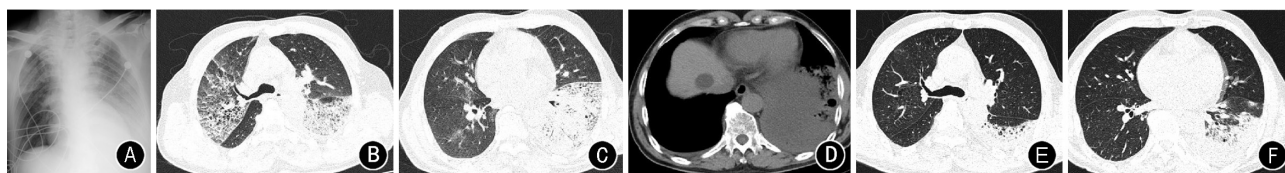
Chest X-ray and CT of a 65-year-old male diagnosed with H7N9 show bilateral, extensive, diffuse ground-glass opacities, consolidation, and reticulation (A–C), with bilateral pleural effusion (D). After treatment, the lung lesions disappeared (E and F) prominently.
